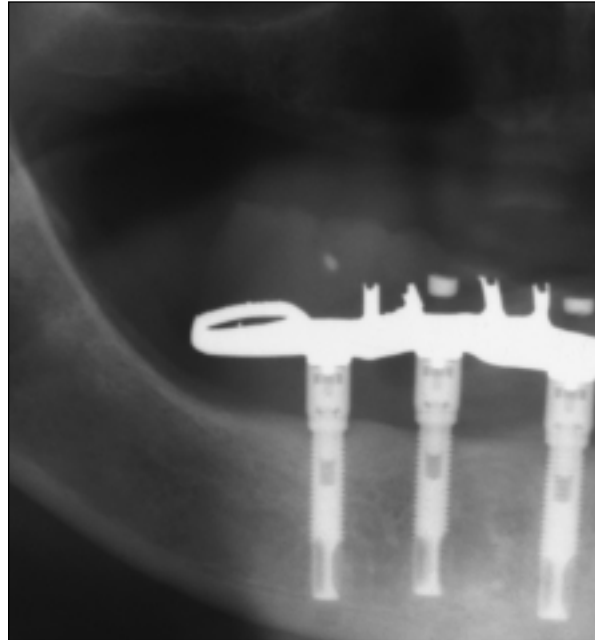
and 2b Radiographs showing the increase in the height of the bony alveolar crest in patient 1. (Left) Image obtained at the time of superstructure fabrication. (Right) Image obtained 25 months after superstructure fabrication.
